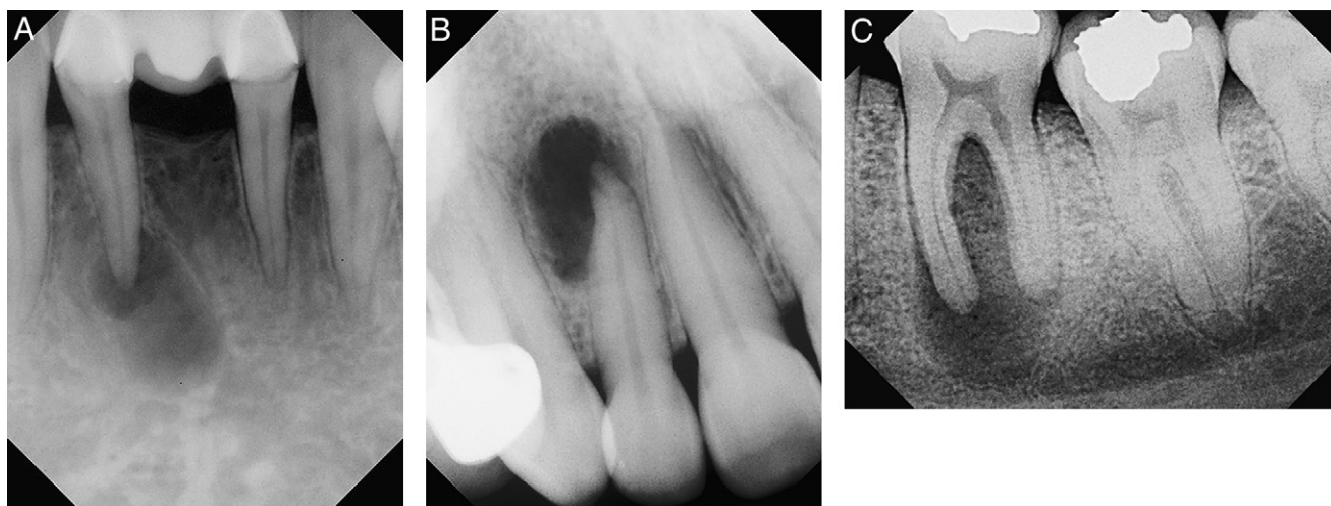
Examples of teeth with significant changes radiographically around the root ends. All teeth exhibit no symptoms or clinical signs of pathosis. (A-C) There is no pain to percussion or palpation and the teeth do not respond to pulp testing. These are typical representations of chronic or asymptomatic apical periodontitis.
